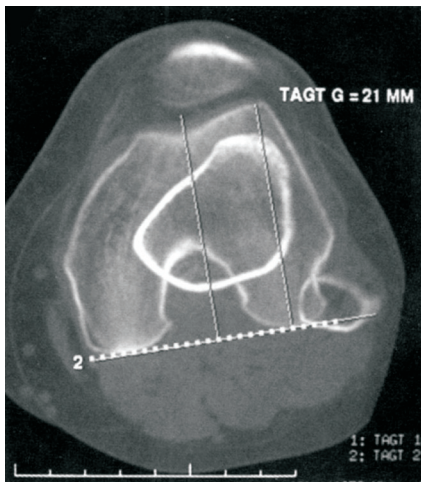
CT image of TT-TG distance.
